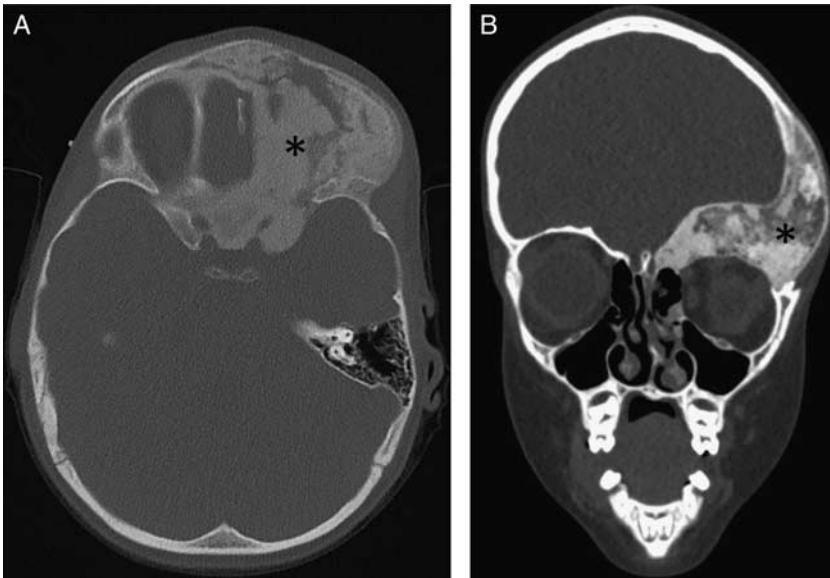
3-year-old boy failed his vision screening test and was noted to have a bony protuberance around the left orbit. Axial (A) and coronal (B) noncontrast computed tomographic images demonstrates an expansile ground glass osseous mass involving the left superior orbital rim, left frontal calvarium, left sphenoid and anterior skull base consistent with fibrous dysplasia (black asterisks). This resulted in narrowing of the optic canal and superior orbital fissure accounting for his visual deficits (not shown).
